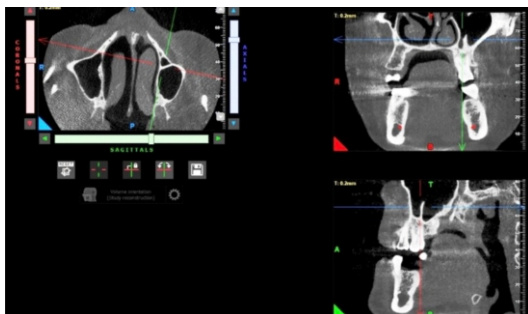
View of septa in CBCT sections
